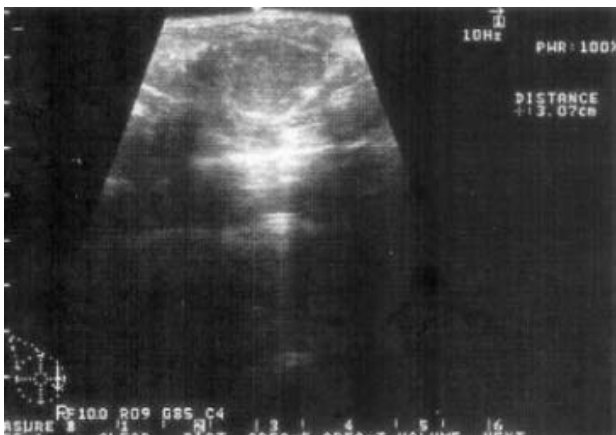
The right breast lump had a well-demarcated margin with homogenous echogenicity on ultrasound examination.
